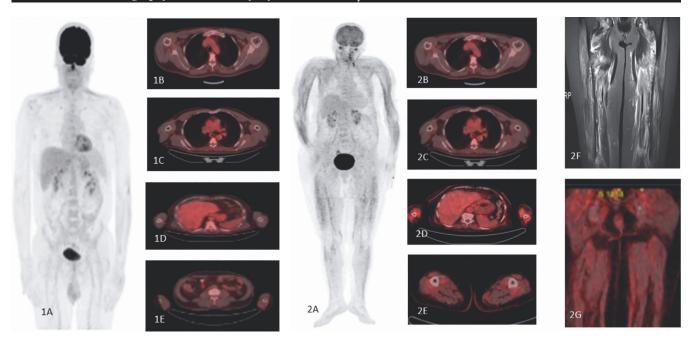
Negative PET-CT scan for muscle involvement.
